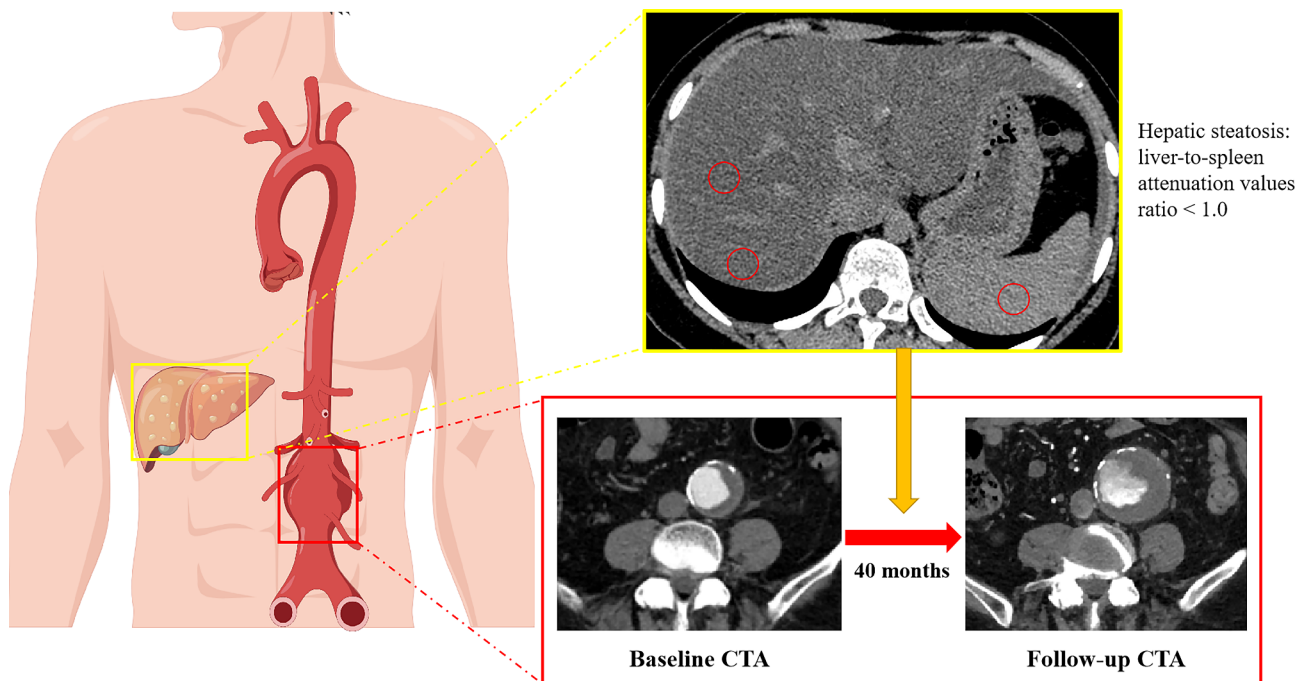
The example of an NAFLD patient with abdominal aortic aneurysm progression. Non-enhanced abdominal CT examination showed the liver-to-spleen attenuation values ratio was < 1.0 , which indicated the presence of NAFLD. CT angiography showed the aneurysm grew from 134.8 mL to 297.0 mL over 3.3 years at a growth rate of 49.2 mL/y. NAFLD, non-alcoholic fatty liver disease
